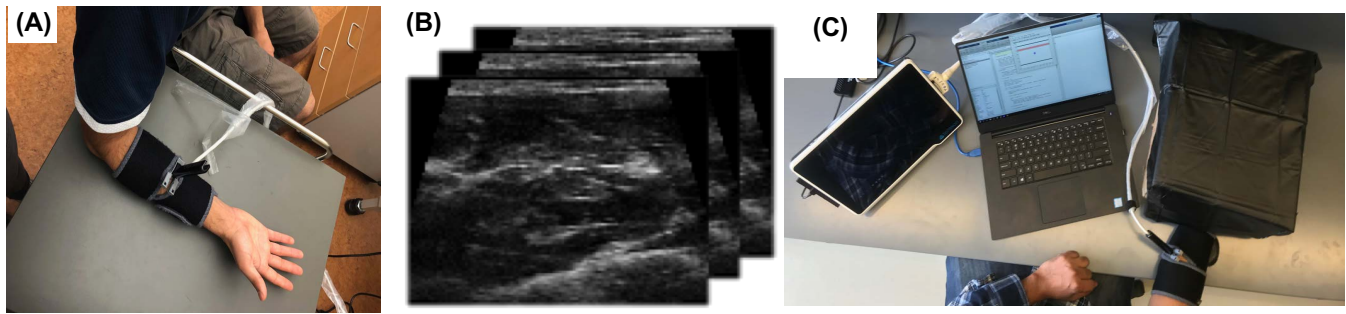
(A) Ultrasound transducer strapped onto the volar aspect of the subjects' forearm and connected to a clinical ultrasound system (B) Cross-sectional ultrasound image sequences are continuously recorded from the forearm and used by the algorithm to derive a proportional signal for controlling the cursor. (C) User's arm is instrumented with an ultrasound transducer and the hand is kept inside an opaque enclosure while the subject is controlling a cursor on a computer screen.
